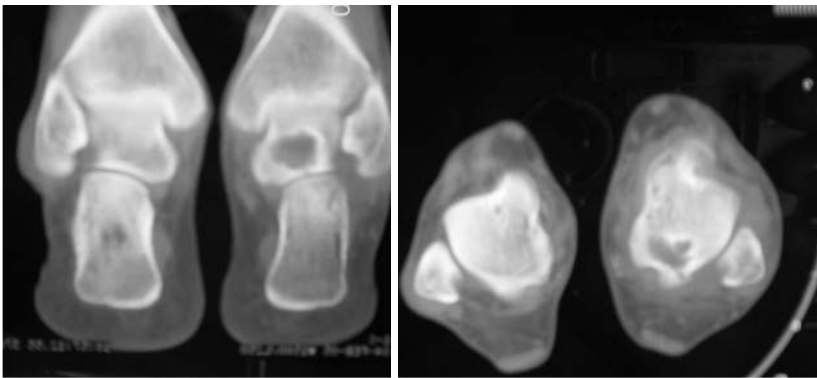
CT scan of both ankles showing lytic lesions in the left talus and right calcaneum without any sequestra/soft tissue shadows.
